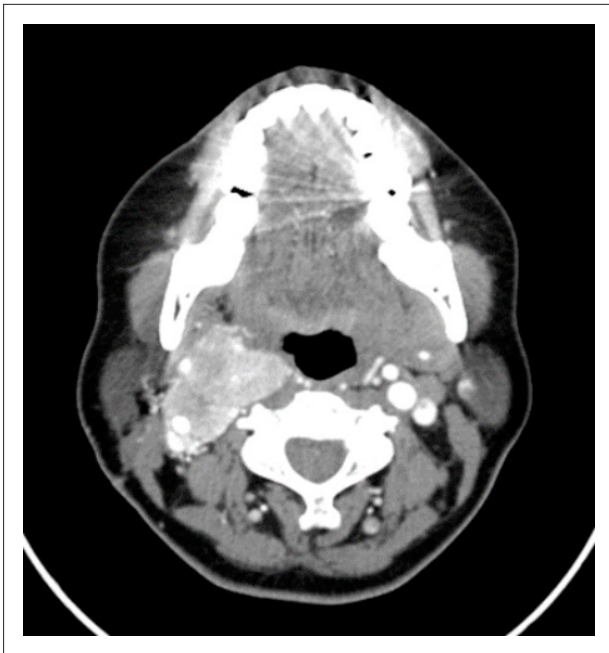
Computed Tomography before radiotherapy.
